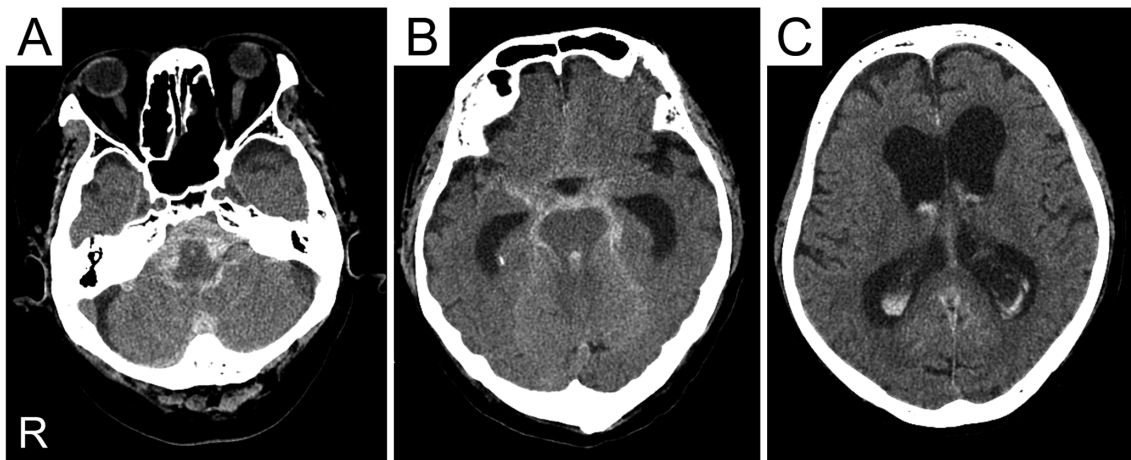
CT showing subarachnoid hemorrhage involving the basal and the suprachiasmatic cisterns with associated intraventricular hemorrhage (A, B) and hydrocephalus with associated intraventricular haemorrhage (C).
